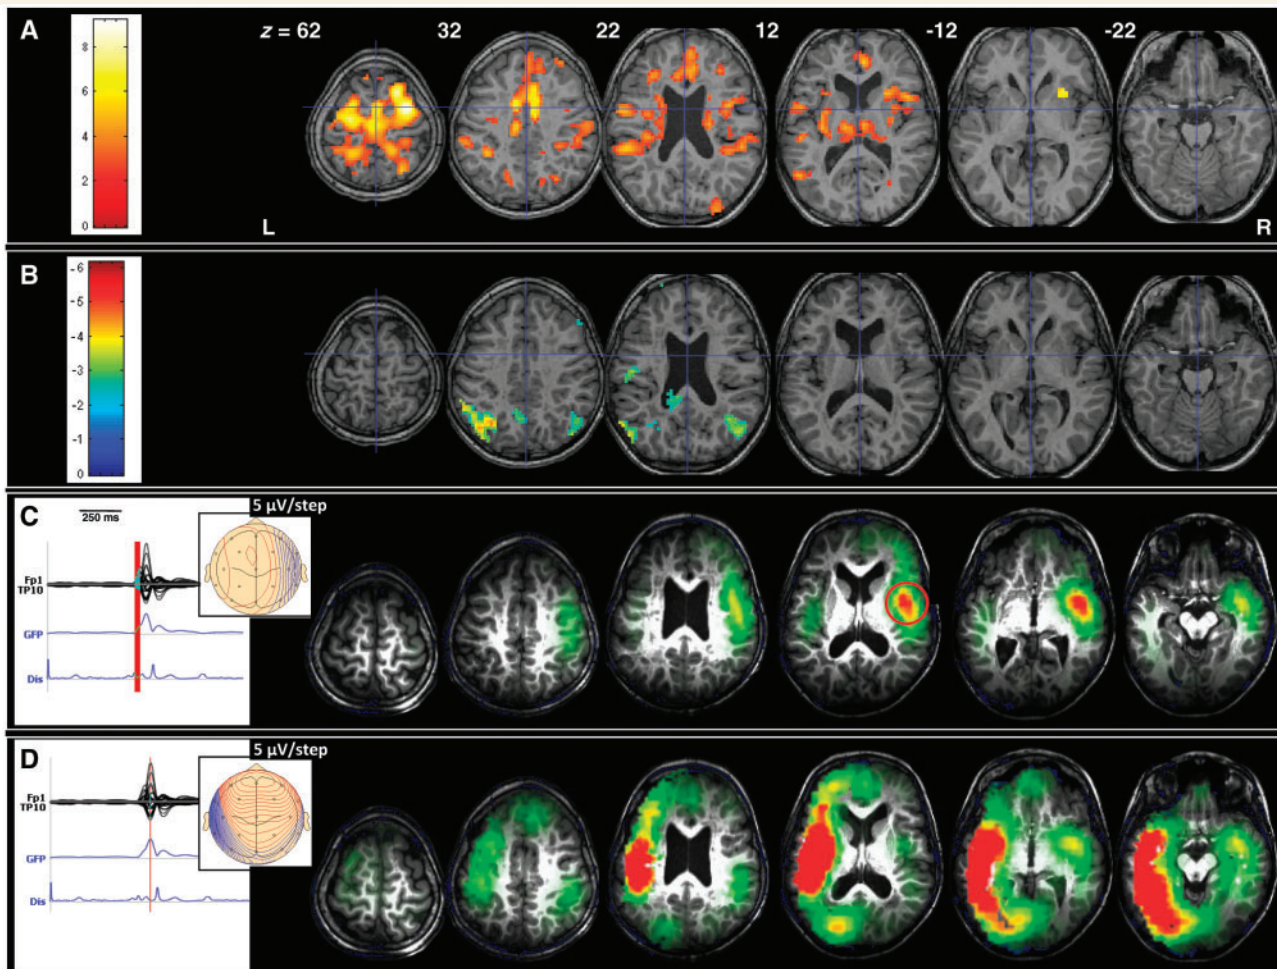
Patient 3: coregistered t -maps (canonical haemodynamic response function, family wise error corrected) with positive (A) and negative BOLD signal changes (B) as well as results of the EEG source analysis for the initial (C) and propagated (D) epileptic activity. Following perinatal complication (haemorrhage with periventricular leucomalacia on MRI), this male patient presented with global mental retardation and simple motor seizures, which tended to generalize into tonic-clonic seizures. At the age of 8, he developed CSWS and showed increase in seizure frequency. Note a good correspondence between the initial epileptic activity and positive BOLD signal changes in the right perisylvian region. The activity propagates into the other hemisphere and involves the left perisylvian area, temporal and parietal cortices. Negative BOLD signal changes can be found in the precuneus and parietal cortex.
